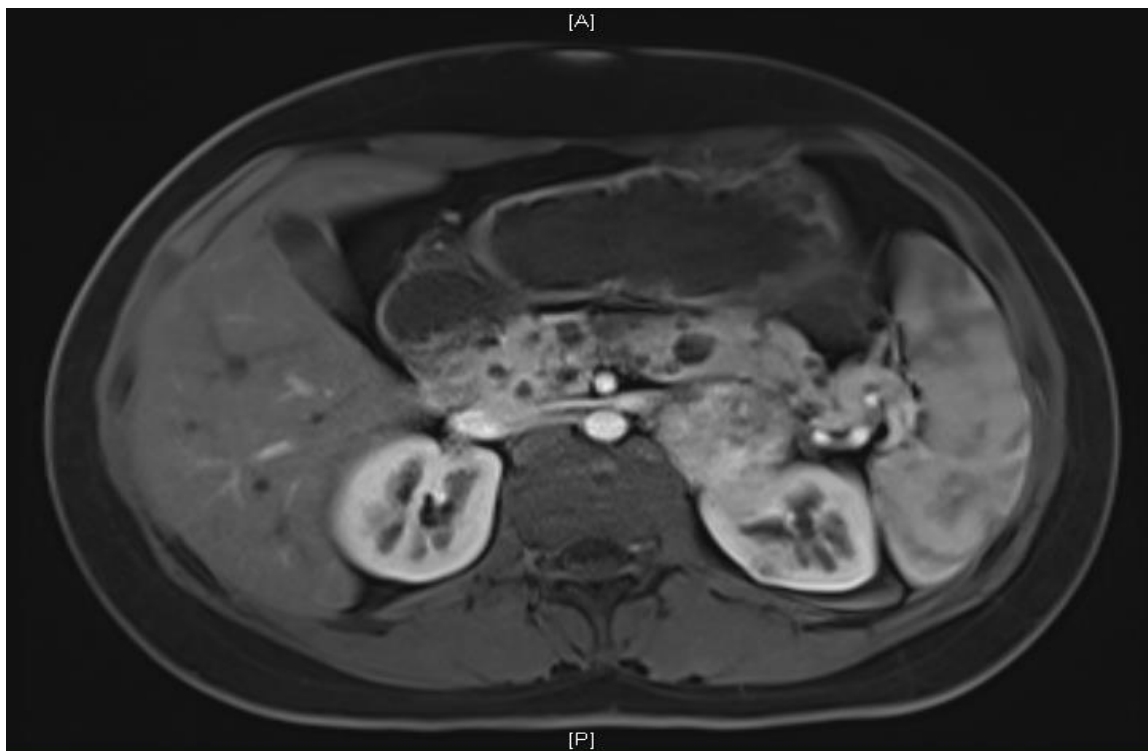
MRI image demonstrating multiple cysts within the pancreas
